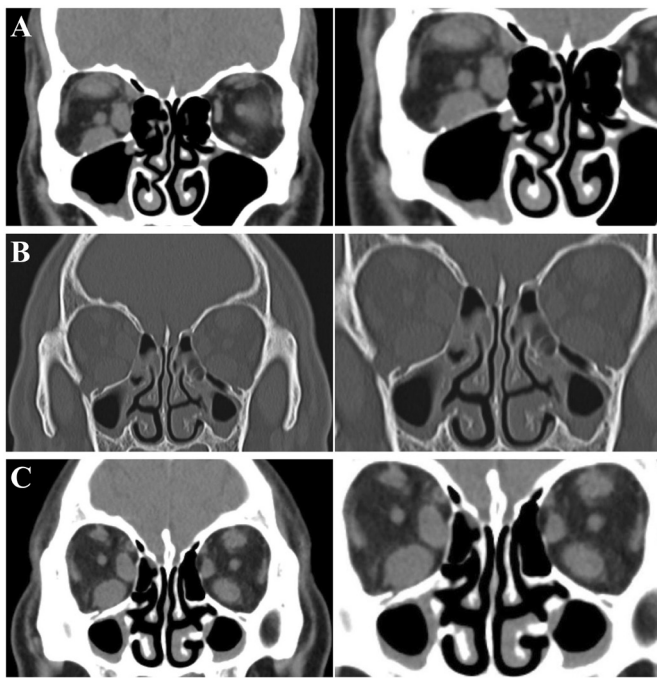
Representative coronal CT images demonstrating EOM enlargement and concurrent paranasal sinus abnormalities in patients with thyroid-associated orbitopathy (higher magnifications are shown on the right) A: Coronal bone window CT image shows unilateral enlargement of the superior, medial, and inferior rectus muscles, accompanied by soft-tissue opacification in the ipsilateral maxillary sinus; B: Coronal soft-tissue window CT image reveals bilateral rectus muscle enlargement, with soft-tissue opacification in the ethmoid and maxillary sinuses; C: Coronal bone window CT image demonstrates bilateral rectus muscle enlargement alongside soft-tissue opacification in the ethmoid and maxillary sinuses. CT: Computed tomography; EOM: Extraocular muscle.
